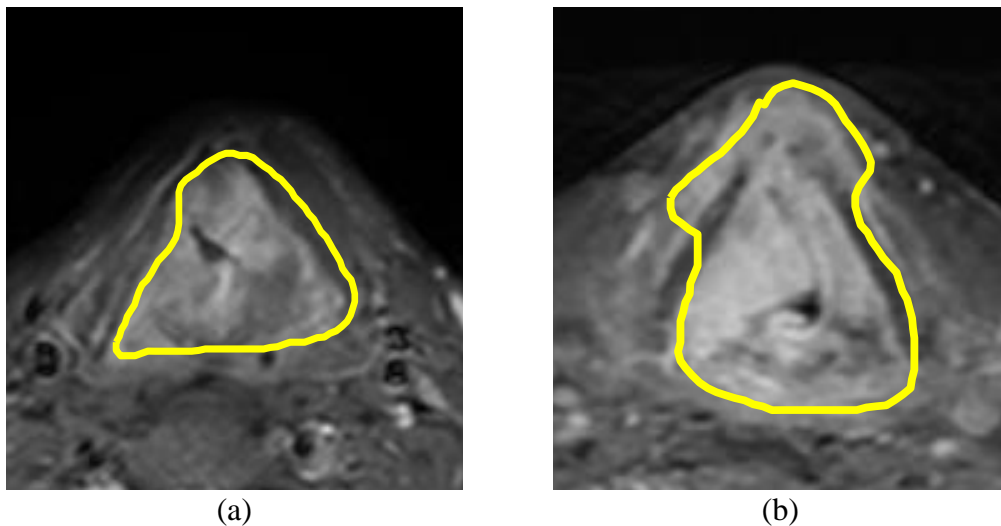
Two example MRI slices with tumour drawn by yellow contours. (a) from MR10062011, (b) from MR27082012. In Both slices, the tumour areas have non-uniform intensity. Shape of two tumours varies. In (b) it can be seen that the bottom and top part of tumour boundaries are fuzzy.
